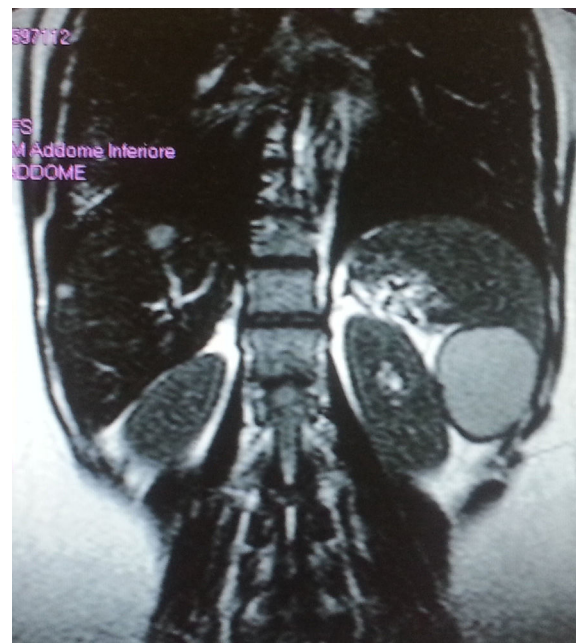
Magnetic resonance imaging of the abdomen (coronal reconstruction) revealed a septated cyst occupying the lower pole of the spleen. The lesion was 6 m × 4 cm in diameter and appeared hyperintense on T2-weighted images, displacing the remaining splenic parenchyma (termed bird-beak sign).
